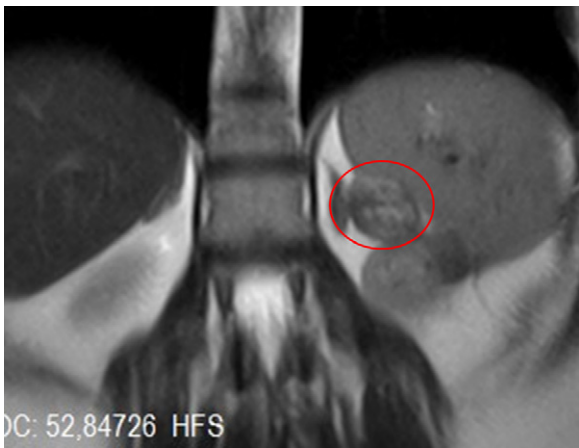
A magnetic resonance image of 30 mm × 20 mm mass with peripheral enhanced ring.
